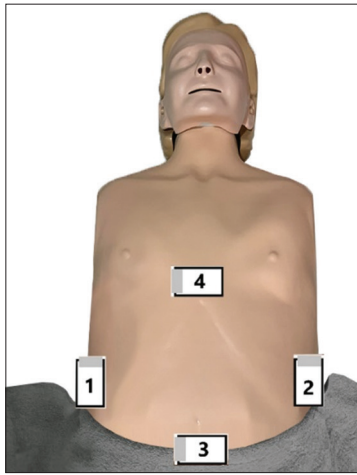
Focused Assessment of Sonography for Trauma assessment of free fluid in abdomen (1–3) and pericardial effusion (4)
